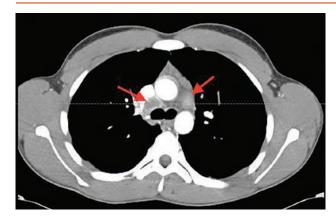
Mediastinal adenopathy (red arrows) as seen on chest CT.
